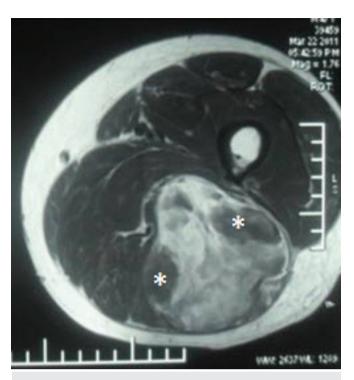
Transverse MR image shows a low-grade liposarcoma in the posterior compartment of the thigh. *confluent globular areas of nonadipose tissue *MR: magnetic resonance*
